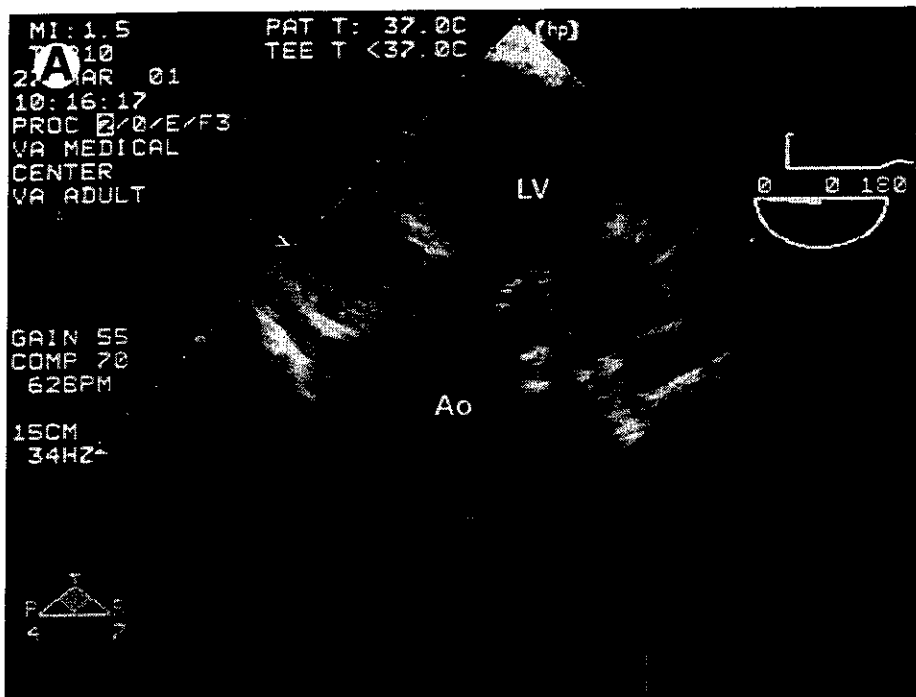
(A) Two-dimensional multiplane esophageal echocardiographic image of the apical transgastric left ventricular out-flow tract view. This position provides an ultrasound beam oriented near parallel to blood flow within the aortic valve. (B) Continuous-wave Doppler signal of aortic blood flow velocities. Abbreviations: Ao, aorta; LV, left ventricle.
